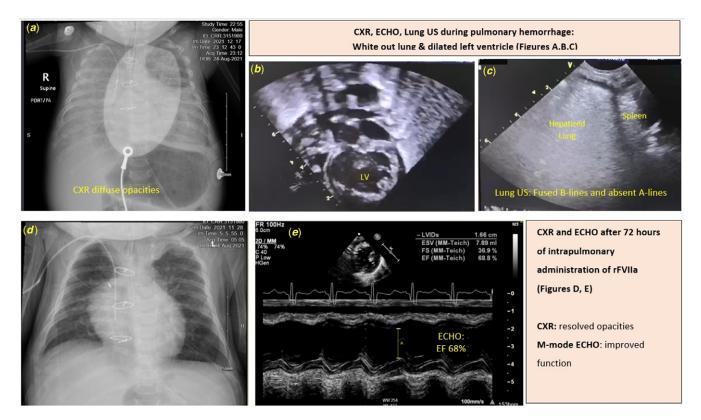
Comparative CXR and point of care US imaging within 72 hours of administration of endotracheal rFVIIa following cardiac arrest and pulmonary haemorrhage, in 3month-old infant with repaired congenital heart diseases. EF: ejection fraction; LV: left ventricle; US: ultrasound.
